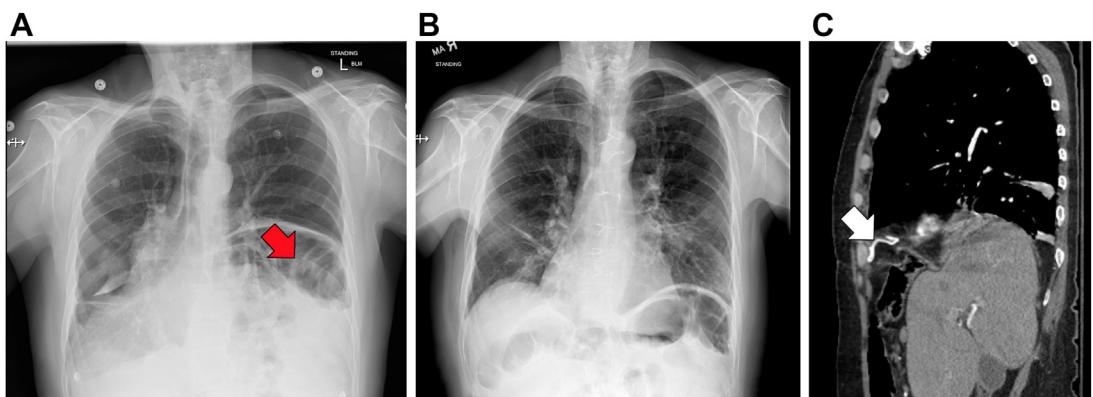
Preoperative (A) and Postoperative (B) chest X-rays of gigantic complex left-sided Morgagni hernia. Red arrow depicts hernia. Sagittal CT scan after repair (C) with white arrow depicting Gore-Tex mesh repair of defect.
